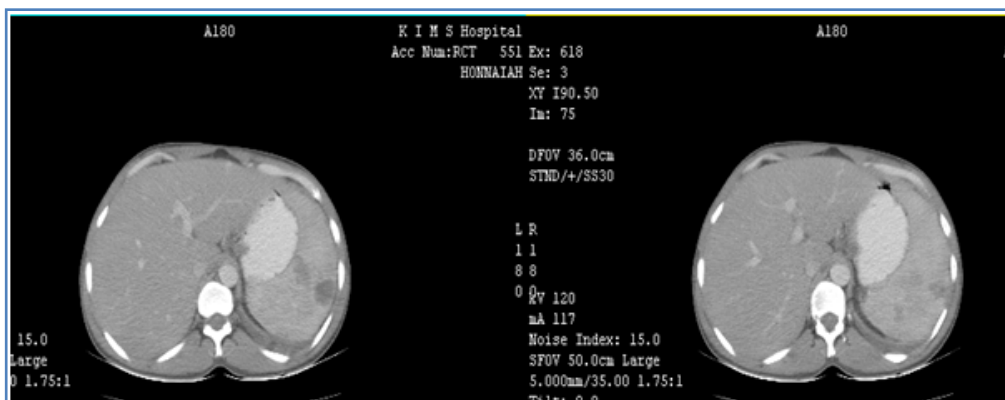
CT abdomen showing multiple hypo echoic lesions in spleen suggestive of infarcts
